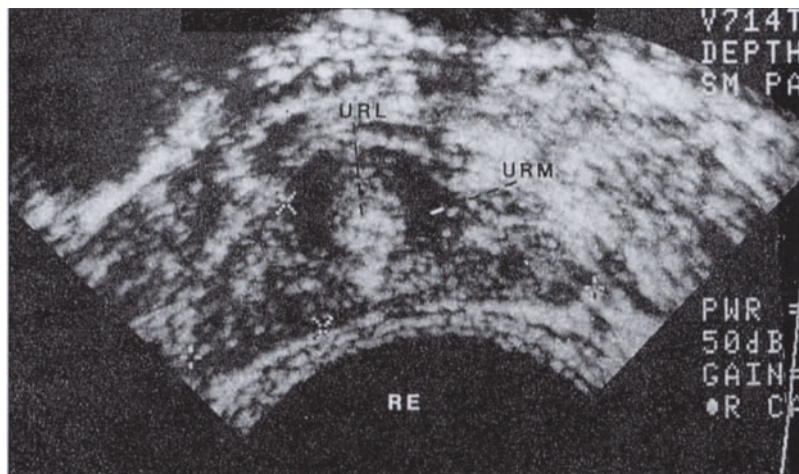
Clinical support of the dihydrotestosterone (DHT) hypothesis. Transrectal ultrasound of rudimentary prostate (indicated by cursors) in male pseudohermaphrodite with 5α -reductase deficiency. Benign prostatic hyperplasia (BPH) does not occur or rarely occurs in men castrated prior to puberty [21]. Numerous clinical studies have documented the regression of BPH and improved voiding symptomatology in men with prostatism following bilateral orchiectomy [22–24]. Male human pseudohermaphrodites resulting from a congenital deficiency of the enzyme 5α -reductase have vestigial prostates, consisting only of a central zone, despite normal serum testosterone levels and no defect in the androgen receptor [25–27]. Administration of DHT results in prostatic growth, indicating that DHT is the primary mediator of prostate growth and that testosterone cannot act alone to support growth and development of the prostate [28]. RE—rectal lumen; URL—urethral lumen; URM—urethromuscular wall. (Courtesy of the *Journal of Clinical Endocrinology*.)
